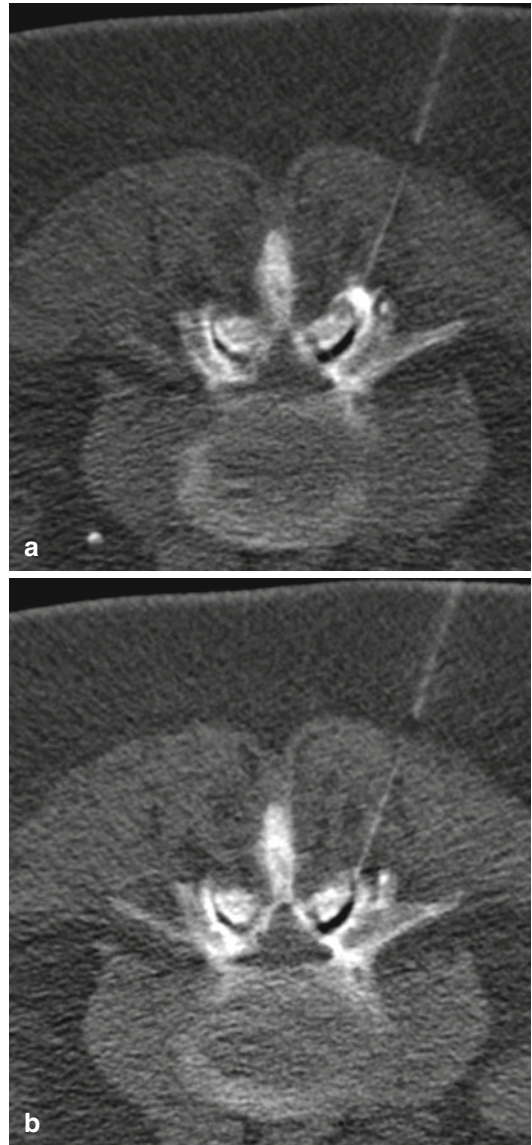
CT-guided fact joint neurolysis. For injection therapy, a 25-G needle was placed in the arthrotic facet joint (a). After injection of approximately 0.1 ml of a contrast medium/NaCl mixture, CT shows a homogenous intraarticular distribution of the contrast medium (b)
